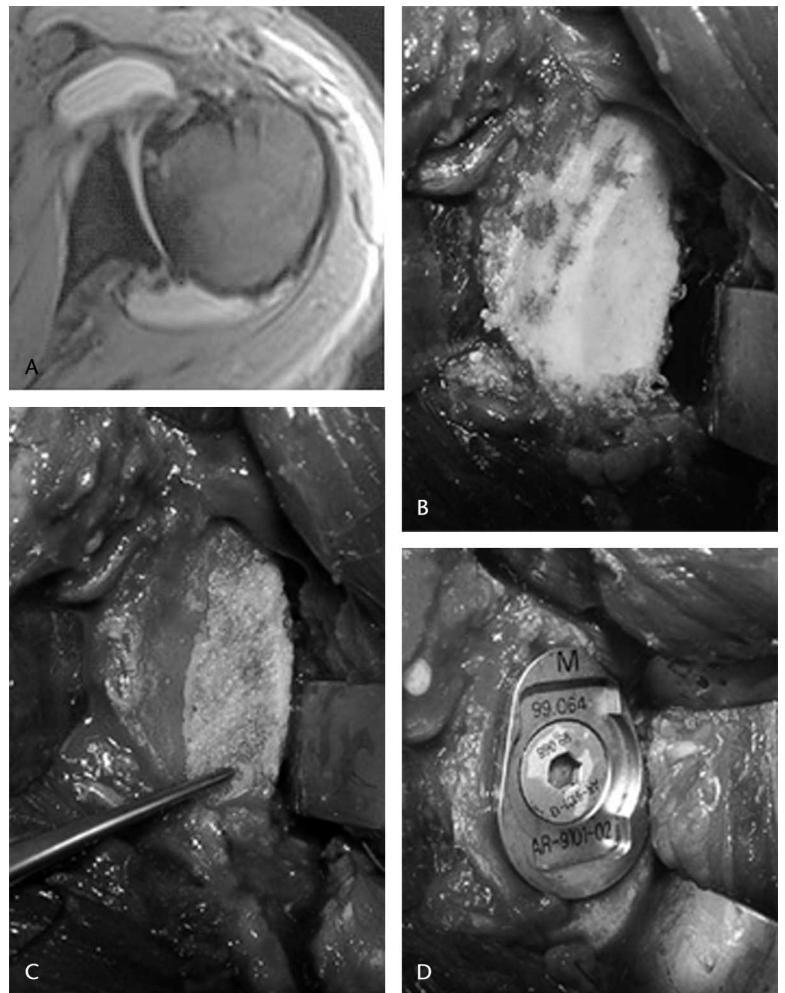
(A) A CT scan shows the transaxial plane with posterior glenoid wear and a posteriorly decentered humeral head. (B) Intraoperative photographs show eccentric glenoid wear before reaming, and (C) an eccentric glenoid after reaming of the anterior high side with a bone graft posteriorly. (D) This intraoperative photograph shows the implanted metal-back component supported by a bone graft.
